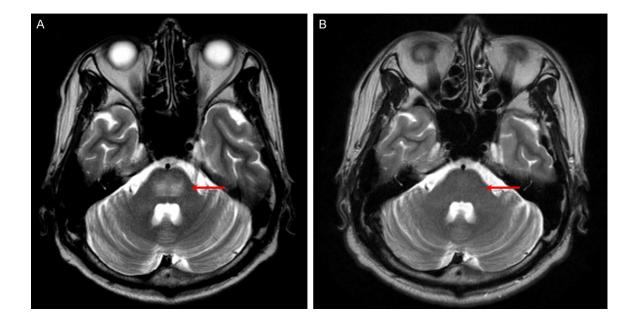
Brain MRI findings (T2W1). A: Before treatment, a high-intensity area can be seen in the central pons on the T2-weighted image, but the surrounding areas remained normal. No contrast enhancing effect is evident, and diffusion-weighted images also show no signal abnormalities (red arrow). B: The abnormal signal in the pons has disappeared after 4 courses of R-CHOP therapy (red arrow).
